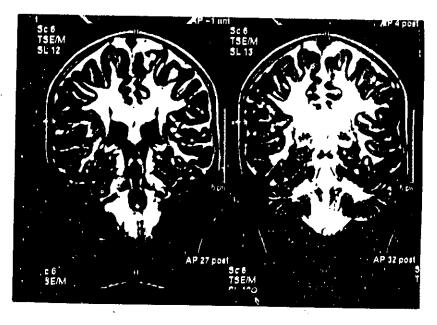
T2-weighted MR image of a 4-years old boy with pelizaeus-merzbacher disease demonstrates difffuse symmetrical demyelination of supratentorial white matter as well as the spino-cerebellar tracts down to the upper cervical cord.
